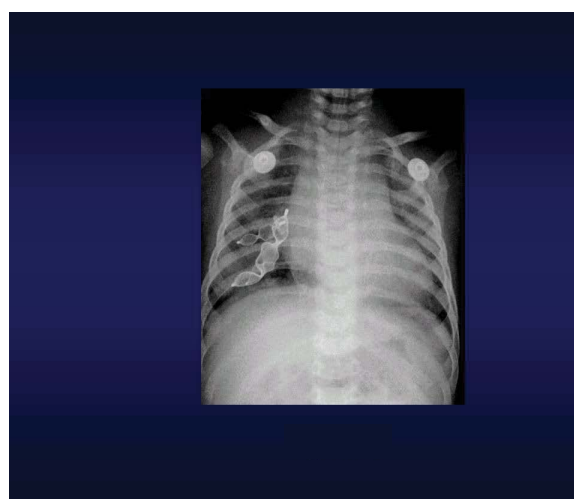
Post procedure chest X-ray showing three vascular plugs in the right lower lung.
